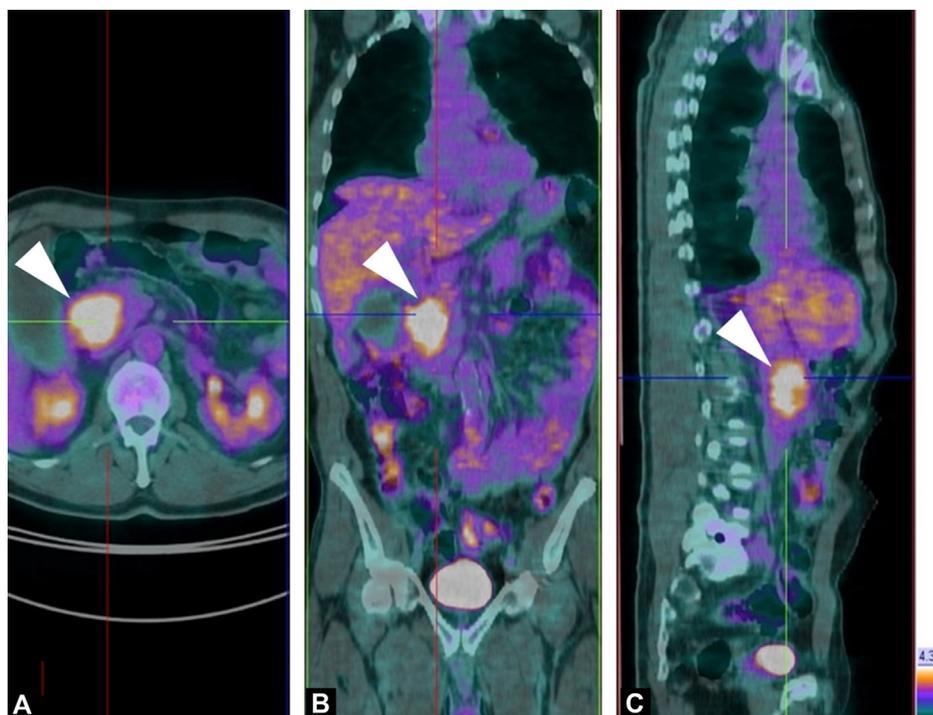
56-year-old man with locally advanced ductal adenocarcinoma of the pancreatic head at initial staging. Fused 18F-fluorodeoxyglucose (18F-FDG) PET/CT images in the axial (A), coronal (B) and sagittal (C) planes show intense focal tumoral uptake of 18F-FDG (arrowheads). Maximum standardized uptake value (SUV max) of pancreatic adenocarcinoma is 12.
